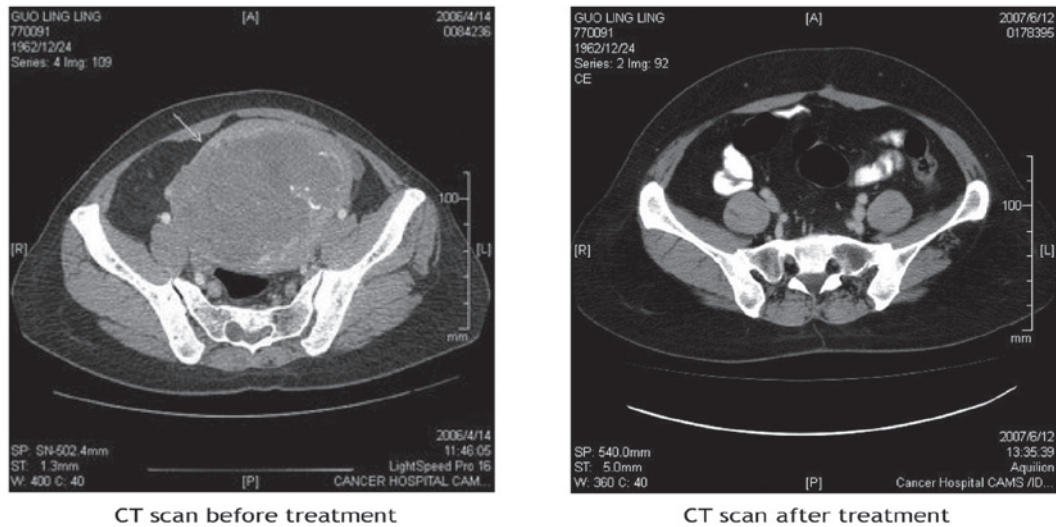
Pre- and post-treatment computed tomography (CT) scans of the surviving patient.
